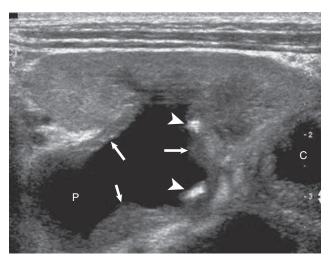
Thickened mucosa and calcifications. High-resolution transverse ultrasound scan of kidney shows mucosal thickening *(arrows)* of calyces and the pelvis *(P)*. There are calcifications of the wall of the calyx and pelvis *(arrowheads)*. A parenchymal cavity *(C)* is also shown. (From reference 23, with permission of the American Institute of Ultrasound in Medicine.)
